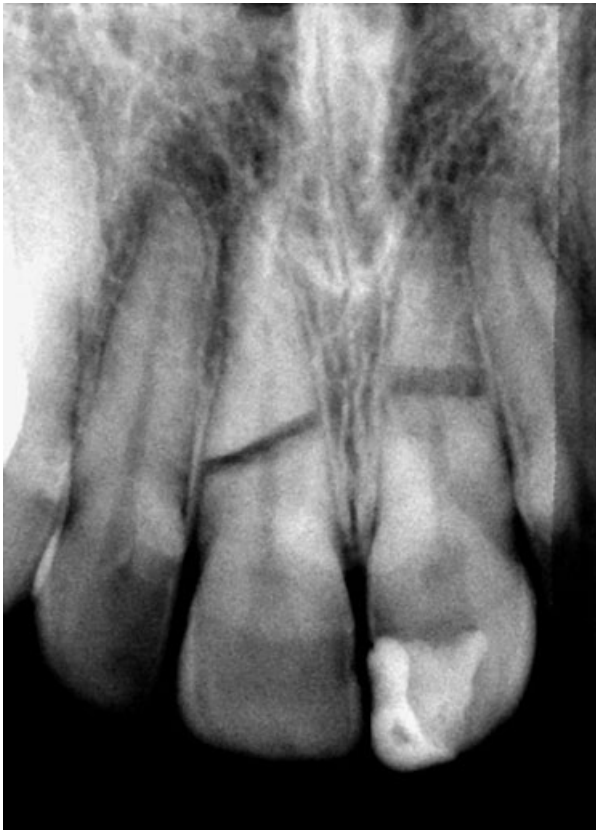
Initial radiographic view.
